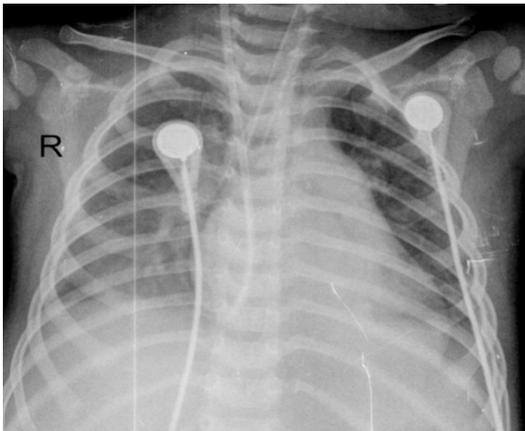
Chest radiography on August 25, 2016 showed a large image in the lower lungs, increased heart shadow and prominent pulmonary artery segment.
